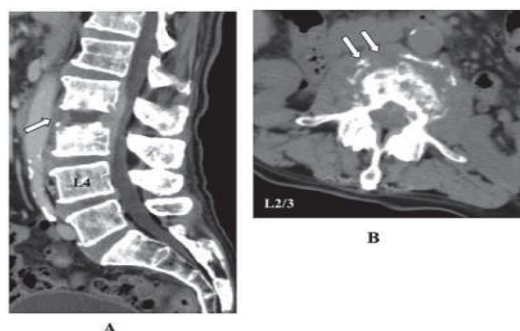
Computed tomography (CT) findings of pyogenic spondylitis in 77-year-old man (same case as Figure 2). Sagittal reformat CT image (A) and axial image (B) show a destructive change at L2-3 (arrow)¹⁴
